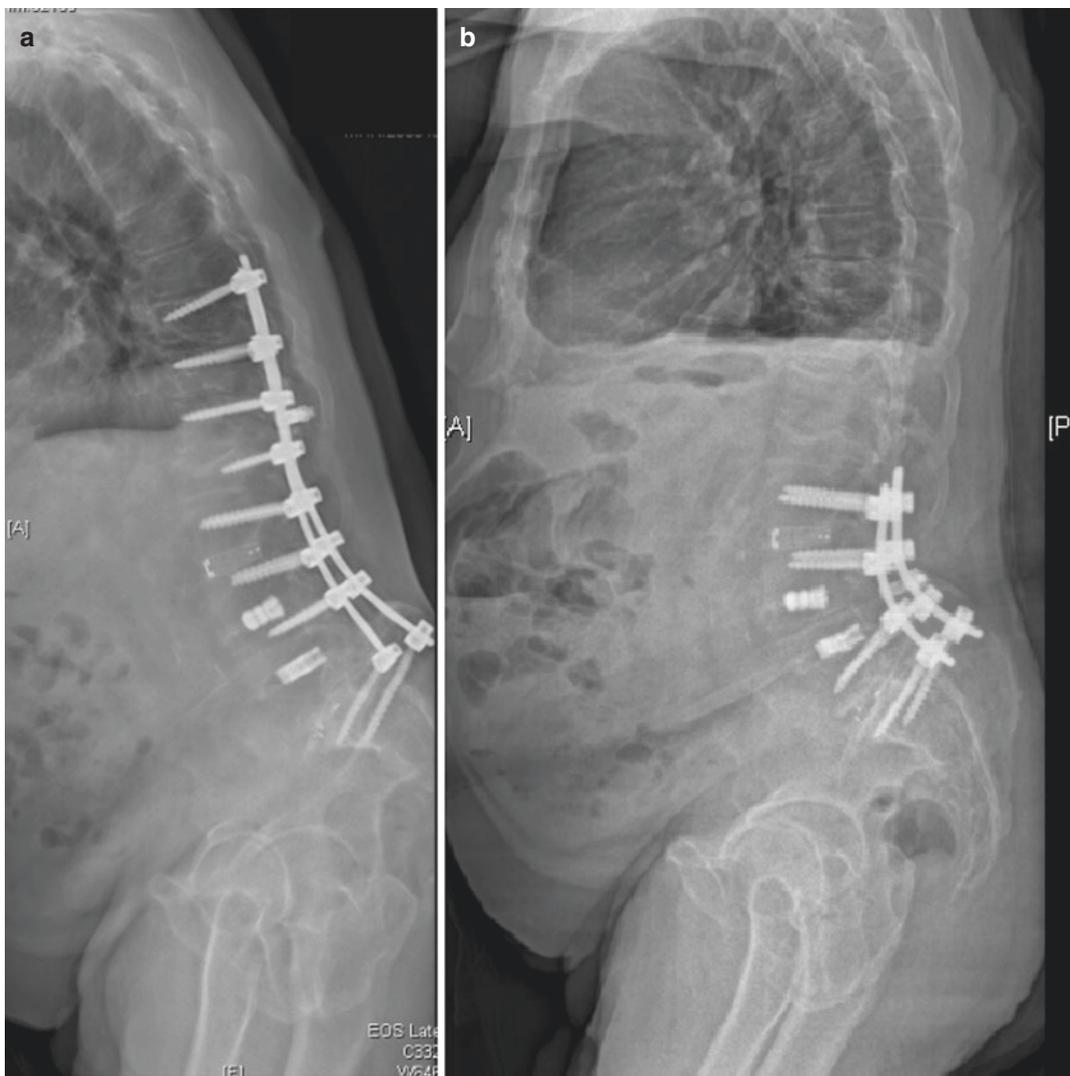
(a) pre-operative lateral X-ray with sagittal imbalance, (b) 3-month postoperative follow-up after partial implant removal and PSO at L4
